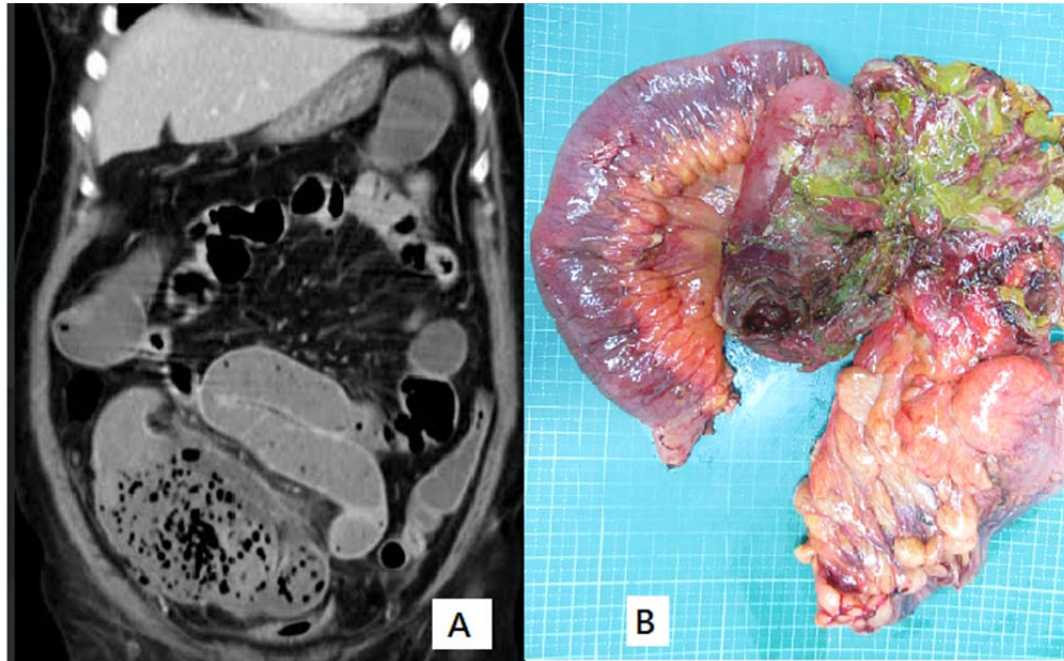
The computed tomography scan of the abdomen showing ischemic bowel with intra-abdominal abscess at right lower quadrant (A) and laparotomy surgery confirming perforation of terminal ileum (B)
